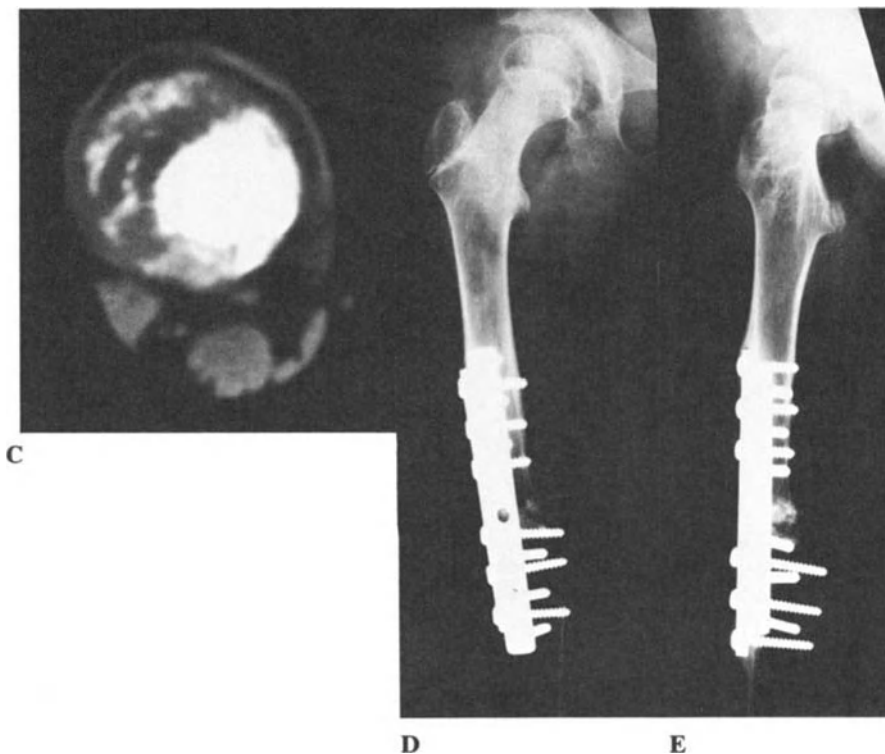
(cont.) C: CT scan shows the extension of the tumor in the adjacent soft tissue. D, E: Wide resection of the tumor and rotationplasty.
